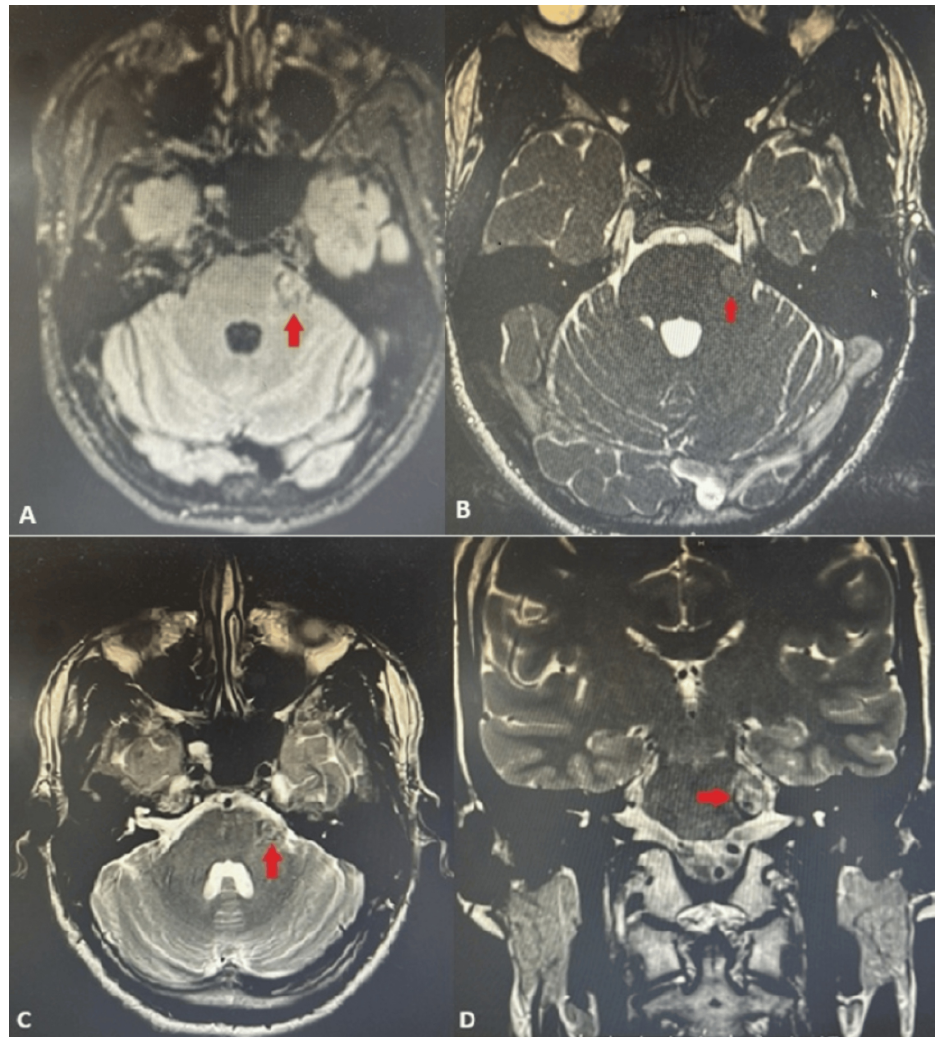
The cavernous malformation is indicated by the red arrow. (A) Axial T1-weighted MRI demonstrating a mildly heterogeneous lesion within the left pons, surrounded by a hypointense rim (red arrow). (B) Axial CISS-weighted MRI showing a well-defined hypointense lesion adjacent to the cisternal segment of the left trigeminal nerve (red arrow). (C) Axial T2-weighted MRI demonstrating a heterogeneous lesion with a peripheral hypointense rim (red arrow). (D) Coronal T2-weighted MRI demonstrating a heterogeneous lesion with a peripheral hypointense rim (red arrow).
